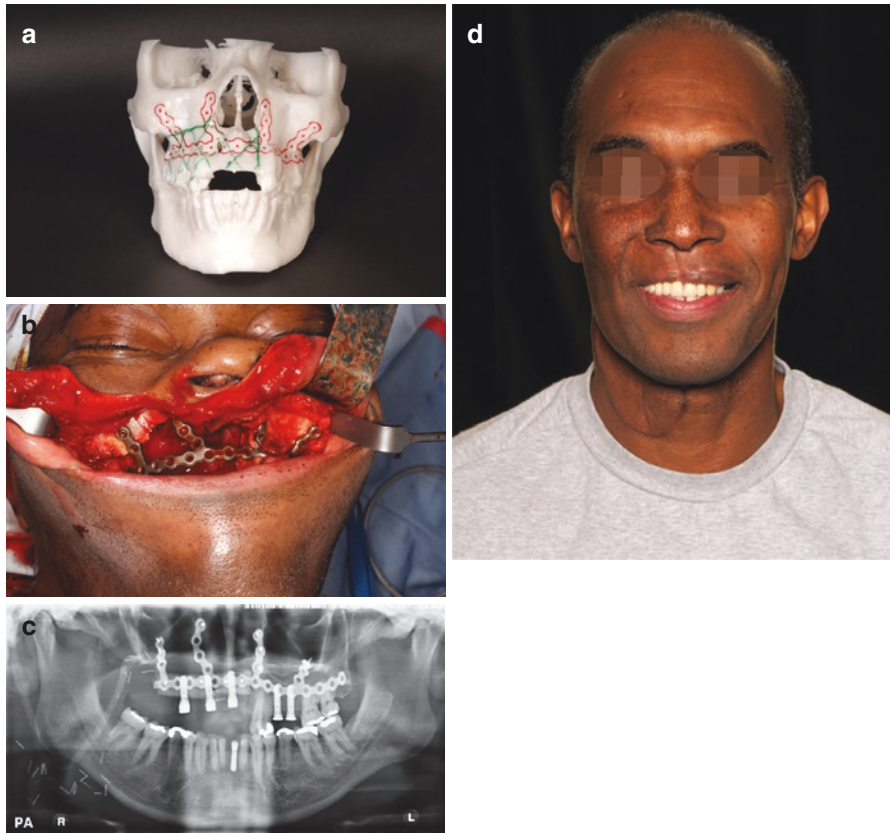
A patient undergoing low maxillectomy for a maxillary tumour, with a fibular reconstruction and dental rehabilitation using osseointegrated implants. (a) Rapid 3-d printed prototype of the patient’s skull created from a CT scan, showing the area to be resected (green) and the intended position of the custom osteosynthesis plates for fibula flap inset time (red). (b) Perioperative photograph showing the excellent fit of the custom-bent osteosynthesis plate. Having these made in advance greatly speeds up the process of flap inset, reducing flap ischaemic as well as overall operating time. (c) A post-operative orthopantomogram, showing the position of the maxillary bone, the customosteosynthesis plates and the osseointegrated dental implants. (d) Final result, showing excellent facial and dental aesthetics. The bent reconstructed patient has near normal oral and dental function
